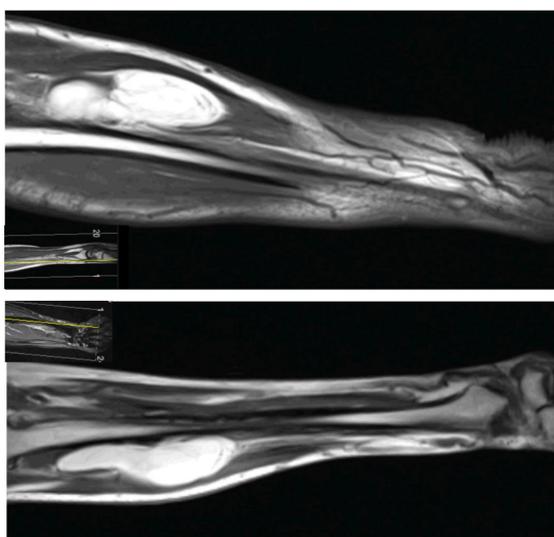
(MRI): Coronal, sagittal and axial views of the proximal forearm.
